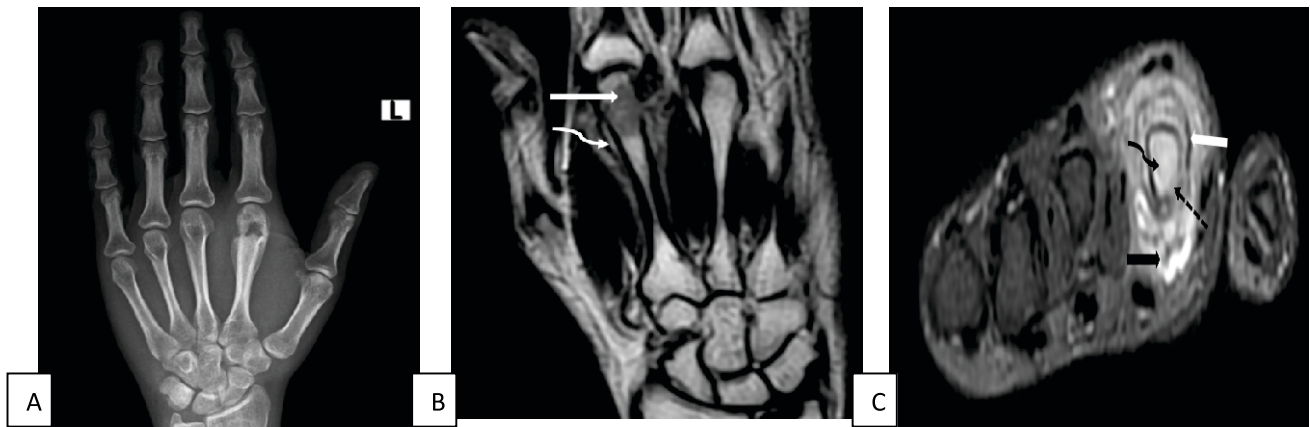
A - Radiograph of left hand (PA view) showing an osteolytic lesion with a narrow zone of transition, surrounding circumferential smooth periosteal reaction in distal metaphysis of second metacarpal. B - Coronal T2 W MRI image showing altered marrow signal intensity (white solid arrow) appearing hypointense compared to surrounding marrow in distal metaphysis of the second metacarpal with surrounding circumferential periosteal reaction (curved white arrow). C - Axial PD-FS MRI image showing marrow edema (curved black arrow) with discontinuity of cortex (dashed black arrow) near anteromedial aspect of distal metaphysis of the second metacarpal with surrounding circumferential periosteal reaction (white solid arrow) and soft tissue edema (solid black arrow).
